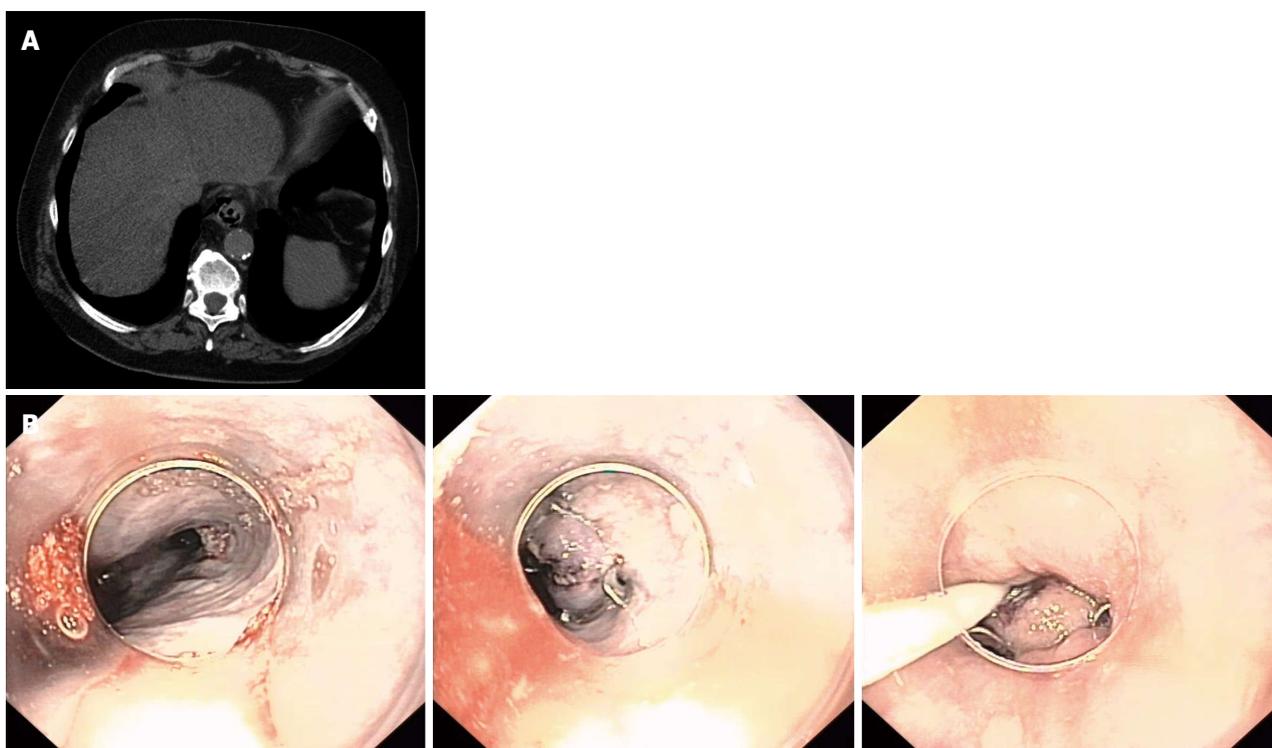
Boerhaave syndrome. A: Computed tomography scan showing the presence of air in the mediastinum; B: Over the scope clip closure of the perforation and feeding tube placement. Taken from Department of Gastroenterology and Internal Medicine, Medical University of Bialystok, Poland.
